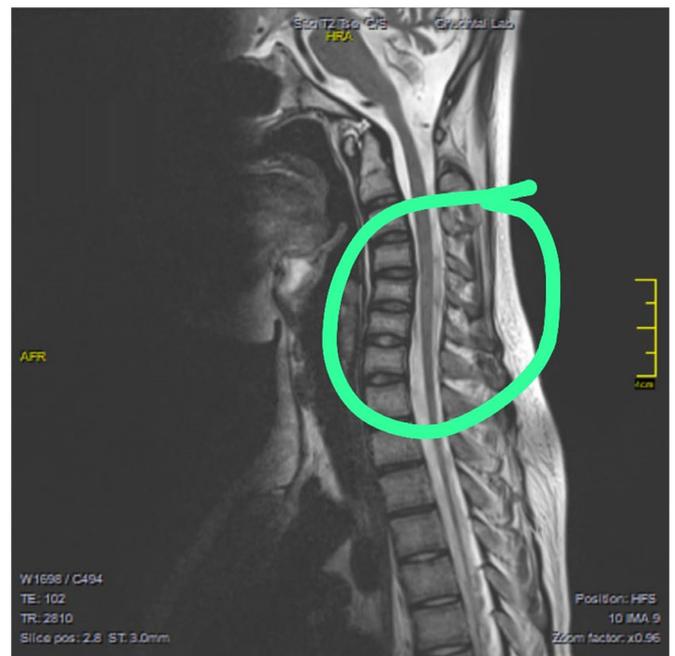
MRI indicating atrophy of the spine in the thoracic region and subacute combined degeneration. The green circle indicates the atrophy.
